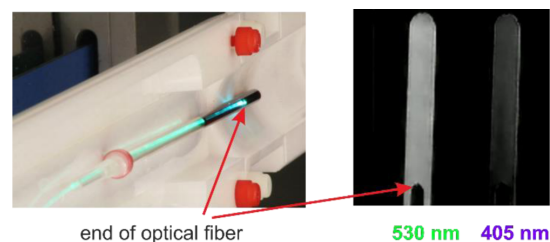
Experimental setup for the contrast switching in a 7 T MRI scanner (left). A 3 mM solution of 1c was irradiated with 530 and 405 nm light, and MRI images were recorded after irradiation (right). A video that demonstrates MRI contrast switching is also available.
